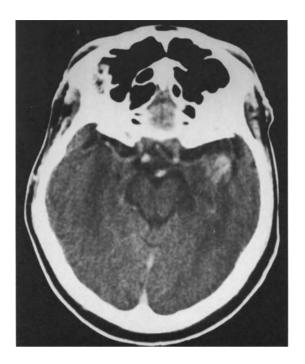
CT of a temporopolar cavernoma in a 22-year-old woman after contrast medium infusion
